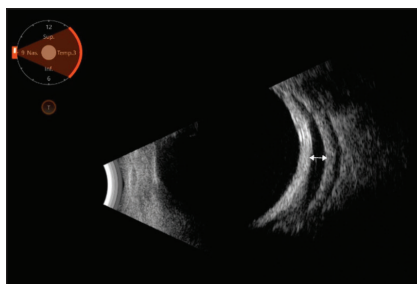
Serous choroidal detachment is demonstrated with a shallow hyperechoic membrane overlying the hypoechoic transudative fluid (white arrow) on B-scan ultrasound.
